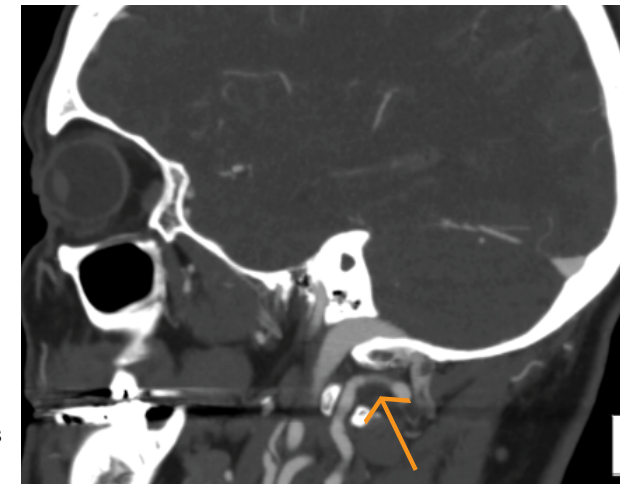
CT angio of the Head: Arrow points to an area of vertebral artery dissection at the V3 segment
